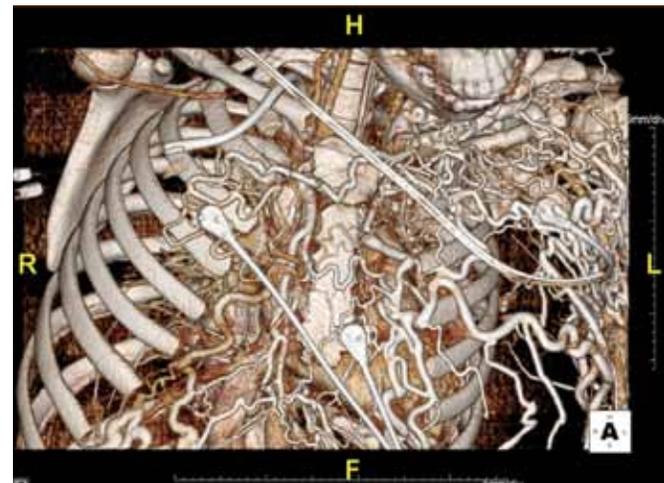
Virtual surgical table view inside Plato's CAVE using GE CTA scan study with TeraRecon, Inc. visualization for planning repair of esophageal varices.
